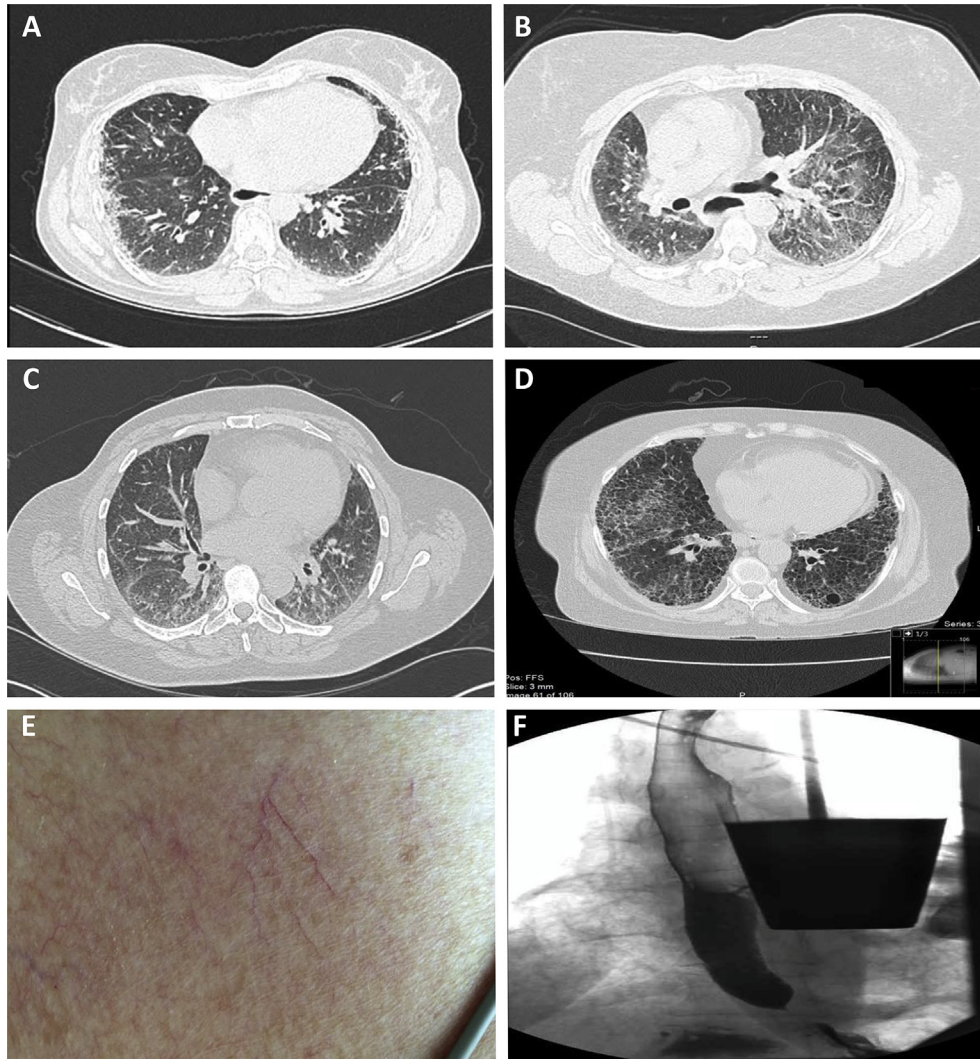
Lung involvement in Ssc-ILD and related abnormalities. A, High resolution chest CT of patient of Case 1. B, High resolution chest CT scan of Case 2. C, High resolution chest CT scan of Case 3. D, High resolution chest CT scan of Case 4. E, Skin telangiectasia detected in Case 4. F, Barium swallow performed in Case 4 showing retention of fluid in esophagus.
